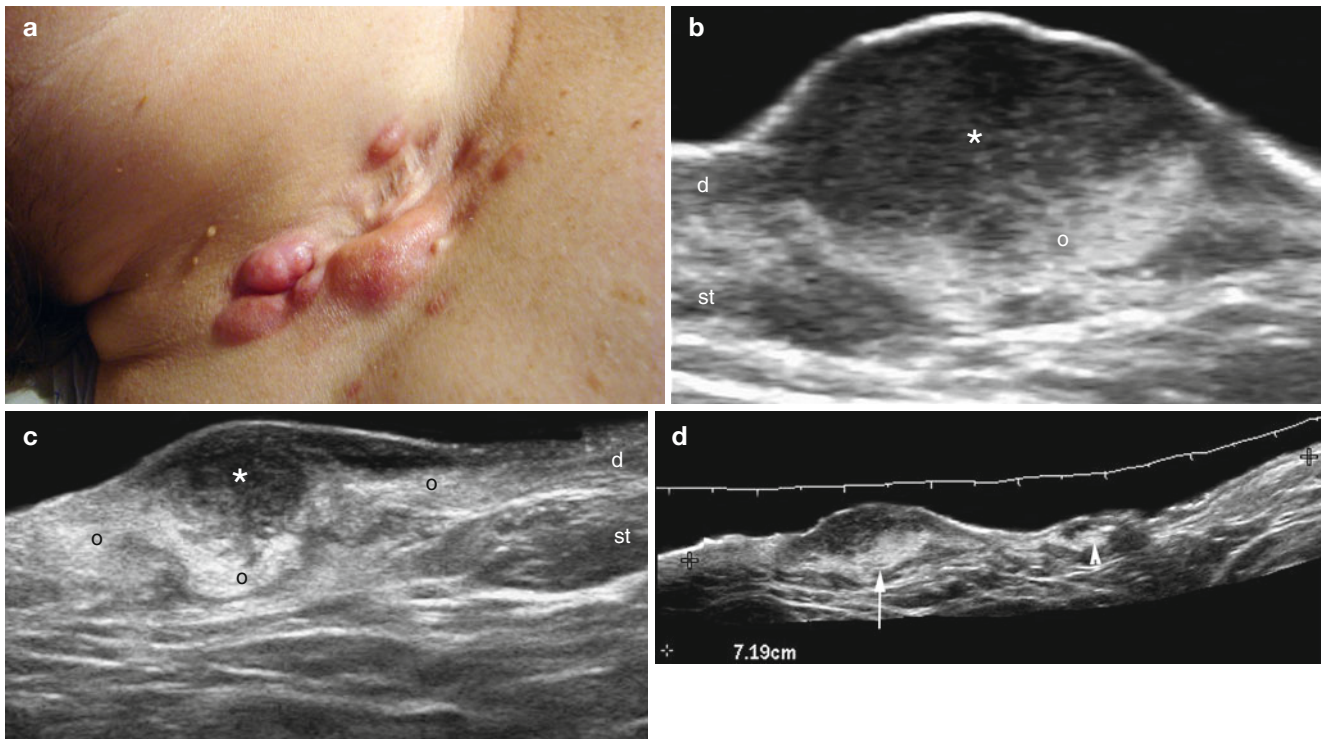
(a–h) Dermatofibrosarcoma protuberans. (a) Clinical image shows erythematous lumps in the right aspect of the neck. (b–d) Grey scale ultrasound images (d: zoomed longitudinal view; c transverse view; d extended field of longitudinal view) demonstrate a 7.19 cm long, ill-defined mixed echogenicity lesion that involves the dermis and subcutaneous tissue. The lesion is composed of a superficial lobulated hypoechoic pseudonodular region (*) and a deep hyperechoic region
